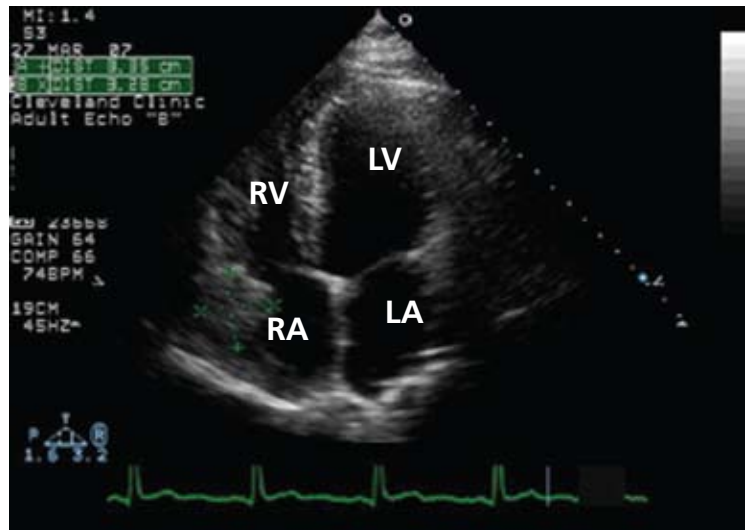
Echocardiogram, four-chamber view, showing the tumor (crosshairs) in the right atrium (RA). LA = left atrium, LV = left ventricle, RV = right ventricle.
